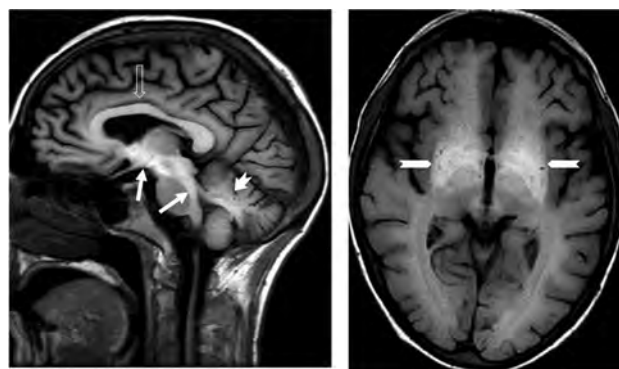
Sagittal (T1-weighted-FLAIR) and axial (T1-weighted spin-echo) images show high SI reflecting Mn deposition in the corpus callosum (open arrow), mesencephalon, crus cerebri, dorsal brain stem, medulla oblongata (white arrows), cerebellum (dentate nucleus) (short white arrow with cut), and basal ganglia (globus pallidus and putamen) (long arrows with cut).
